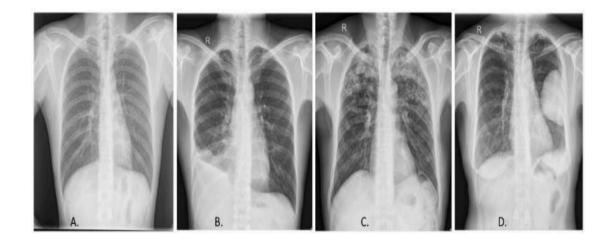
Chest X-ray in (A) indicates normal X-ray, whereas (B), (C), & (D) X-rays expose pleural effusion, infiltrates, and cavity lung lesions (Mukherjee et al., 2023b).
